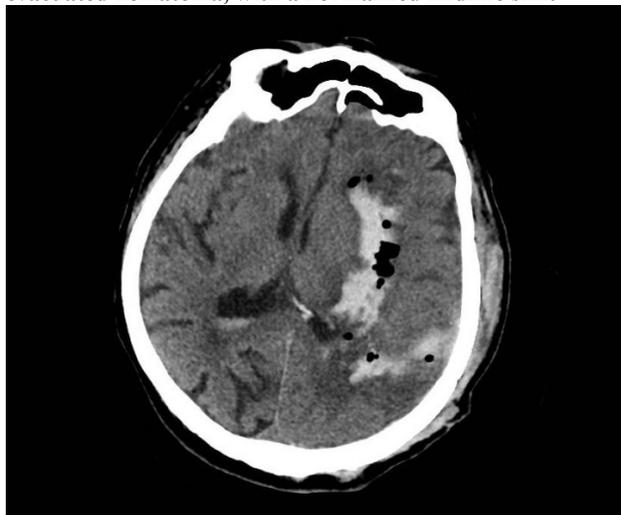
Preoperative CT scan revealing an intraparenchymal fronto-temporo-parietal left hematoma with significant midline shift
